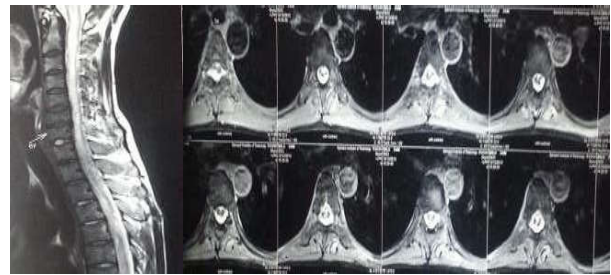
MRI (with contrast) of spine showing diffuse leptomeningeal seeding and syringomyelia.
